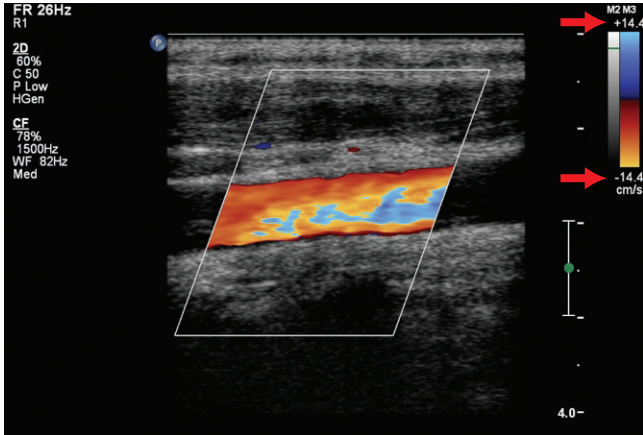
Color Doppler of the common carotid shows the vessel to be widely patent. The vessel is moving toward the head and should be red (away from the transducer). There is blue and yellow in the center of the vessel due to aliasing. Note the low color scale (arrows). A low scale improves color filling but can lead to the aliasing artifact.
